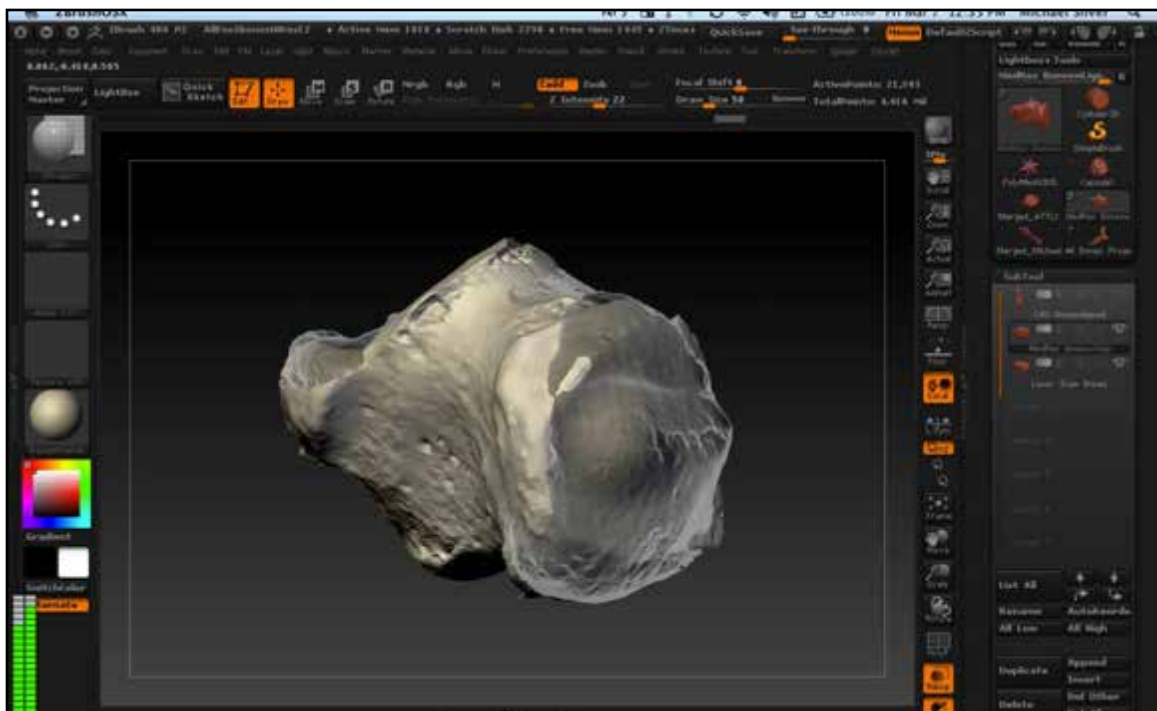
Incomplete CT mesh deep within laser scan mesh in posterior calcaneus area.
